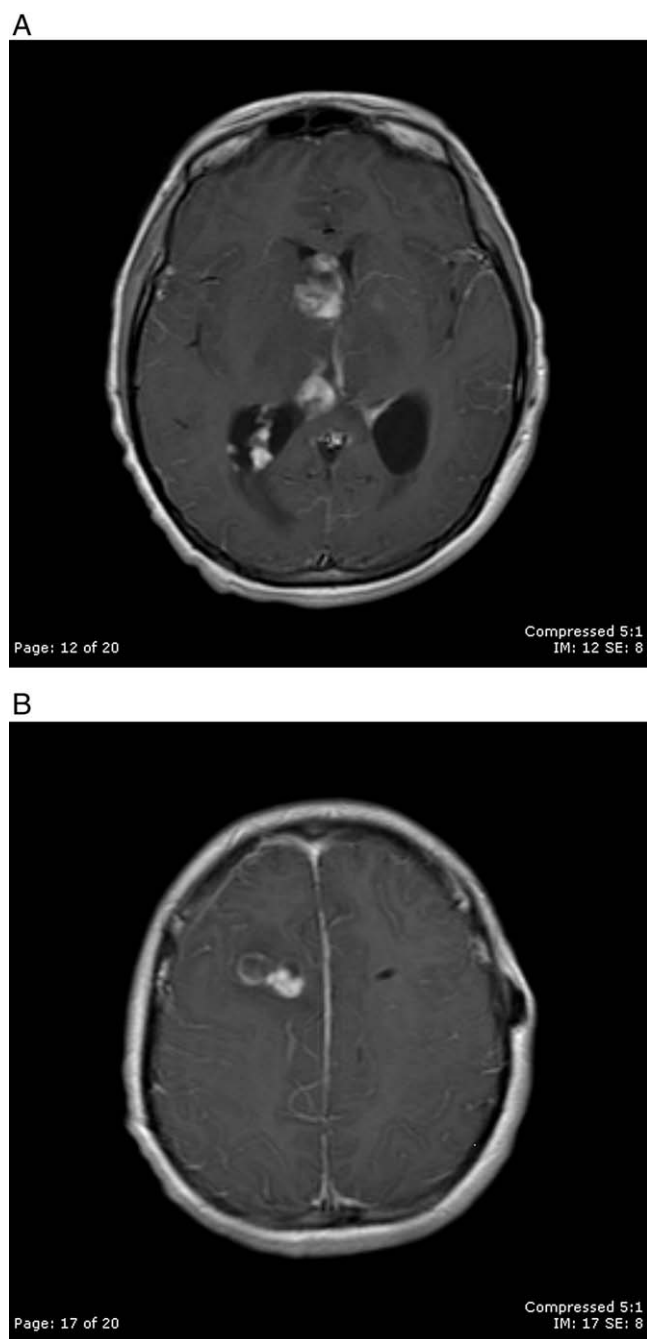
A and B: Follow-up postcontrast T1-weighted axial MR imaging upon readmission several weeks after resection demonstrates rapid recurrence of the mass throughout the lateral ventricles (A) with invasion along the right frontal VP shunt tract (B).
